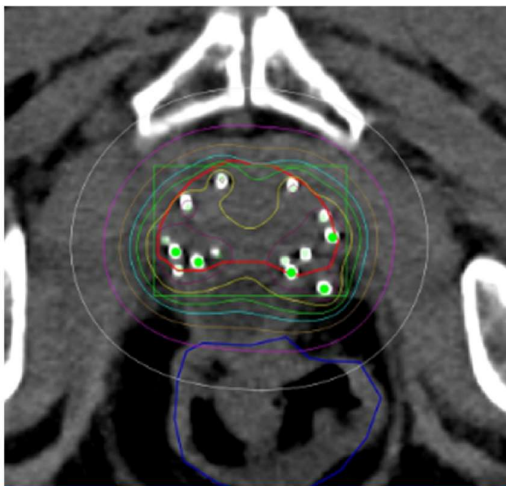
Axial CT slice from an ^{125}I prostate implant, with dose color overlays: most of the gland is covered by the prescription dose (red), but high-dose "hot spots" (>120%) are visible (yellow), and areas receiving less than 40% are shown in purple—demonstrating inhomogeneous dose distribution typical for brachytherapy. Source: *ResearchGate*
